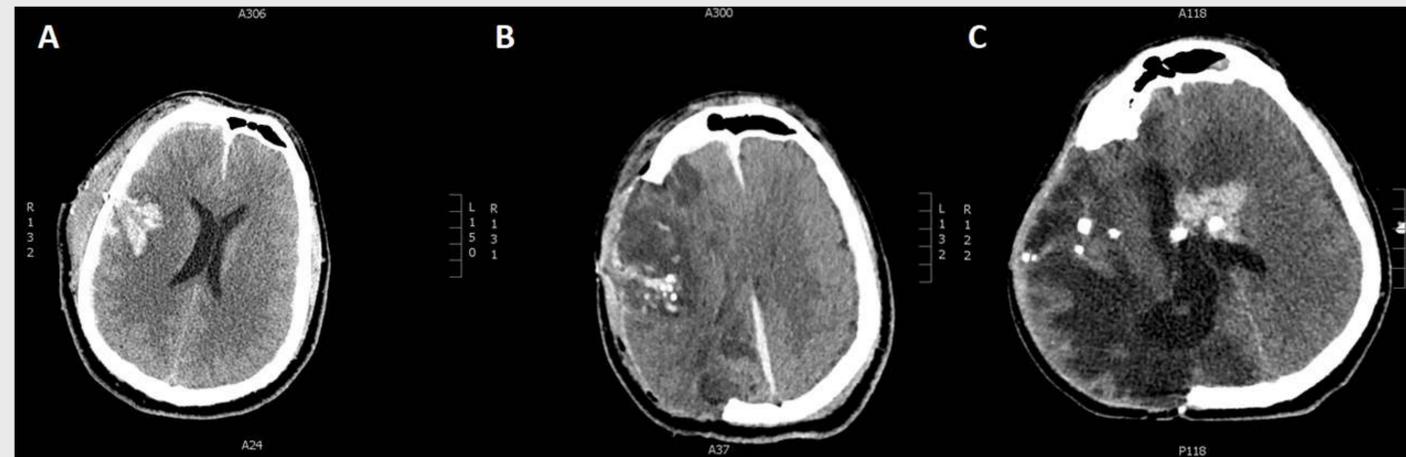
Non-contrasted computed tomography, axial views of the head and brain. A. Hospital Day 0; penetrating traumatic injury showing subarachnoid and intraparenchymal hemorrhages, and subdural hematoma with 6.8mm midline shift. B. Hospital Day 6; status-post craniectomy, with ischemic changes and retained bullet fragments. C. Hospital Day 28; status-post bilateral ventriculosotomy, evolving hemorrhage and ventriculomegaly demonstrated.
